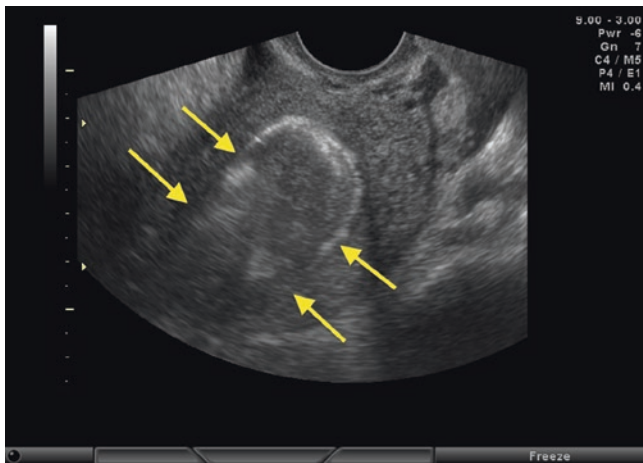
Endometritis: Endovaginal ultrasound, in a patient with abdominal pain, vaginal bleeding and fever for 2 days. The image shows the thickened and hyperechoic endometrium, with undefined limits for the most part (between the arrows). The diagnosis of endometritis is often a challenging task, as signs and symptoms are non-specific and the sonographic findings are variable; these include thickening and irregularity of the endometrium, and fluid or debris accumulated within the endometrial cavity
